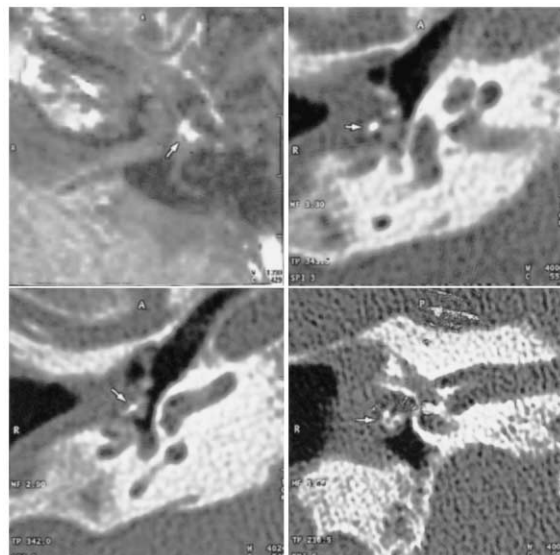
Two patients with acute facial nerve palsy after middle ear surgery within the first postoperative week. Upper line left: a patient after stapedotomy because of otosclerosis (CT, not shown, documented a correct position of the prosthesis). Axial postcontrast T1-weighted image shows strongly enhancing inflammatory tissue in the oval window contacting the facial nerve (arrow). Intraoperatively, the bony canal was partially damaged. Symptoms cleared under conservative therapy. Upper line right, lower lines: a patient after mastoidectomy and insertion of PORP because of chronic otitis media. Two axial and one coronal CT scans show a dislocation of PORP (arrow) contacting the second knee of the facial nerve. CT finding was confirmed by retympanotomy.
